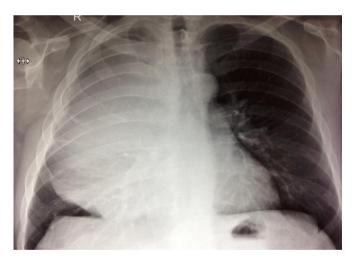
X-ray chest showing a large intrathoracic mass.
